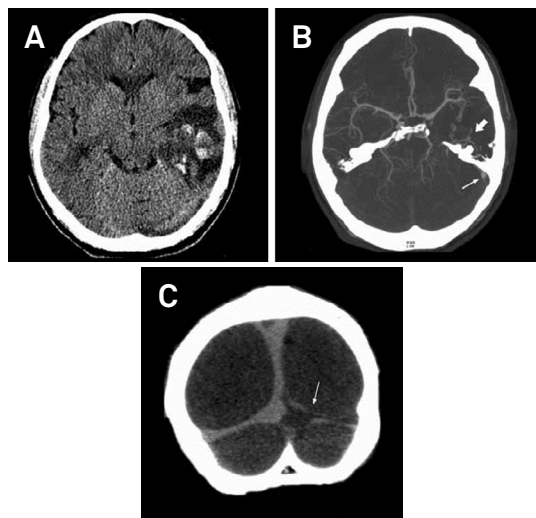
Hematoma in the left temporal lobe identified by computed tomography (CT) (A). CT angiography (CTA, arterial phase, B) showed a vascular structure and early enhancement inside the left sigmoid sinus (thick arrow), as well as serpiginous vessels in the middle cranial fossa (thin arrow). CTA (venous phase, C) showed venous thrombosis (arrow).
